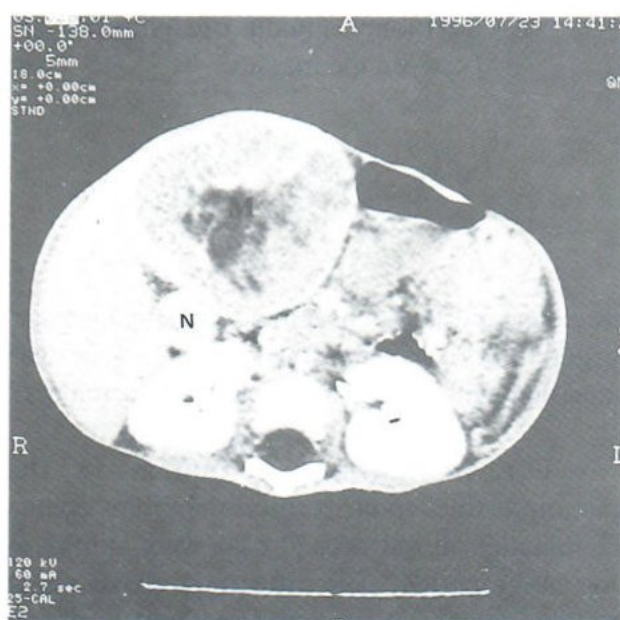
Follow-up CT scan shows a 6-cm mass (M) in caudate lobe. Note rim enhancement, hypodense center, and enlarged lymph node (N).
